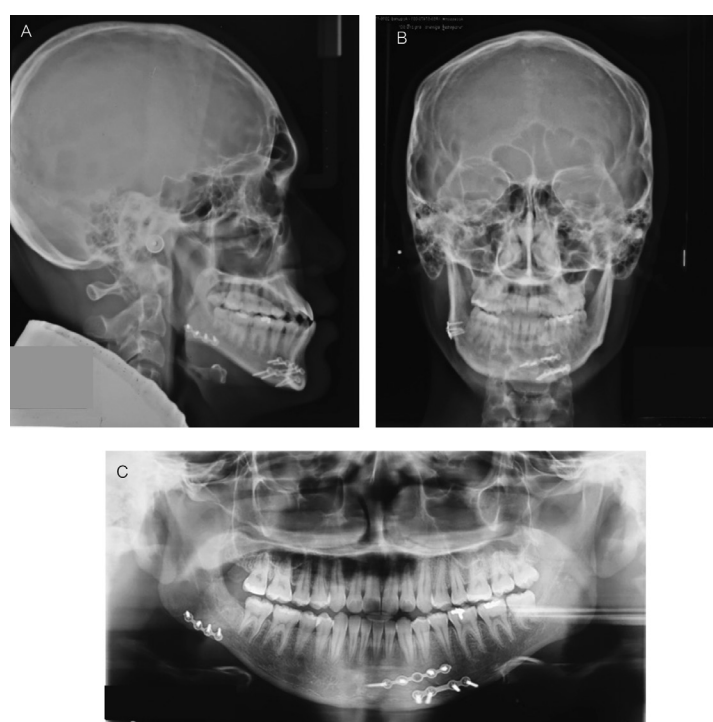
Pre-treatment (A) lateral cephalogram, (B) postero-anterior cephalogram, and (C) panoramic radiograph.
